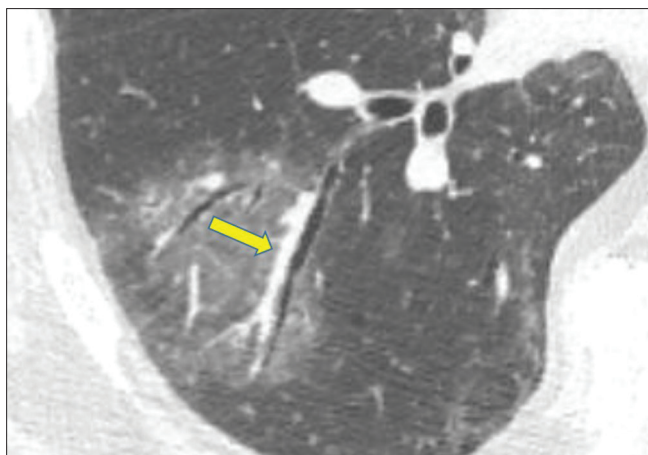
A 65-year-old male coronavirus disease 2019 patient presenting with fever and cough for 10 days. A computed tomography scan shows a ground-glass opacity in the right lower lobe with vascular enlargement (yellow arrow)
